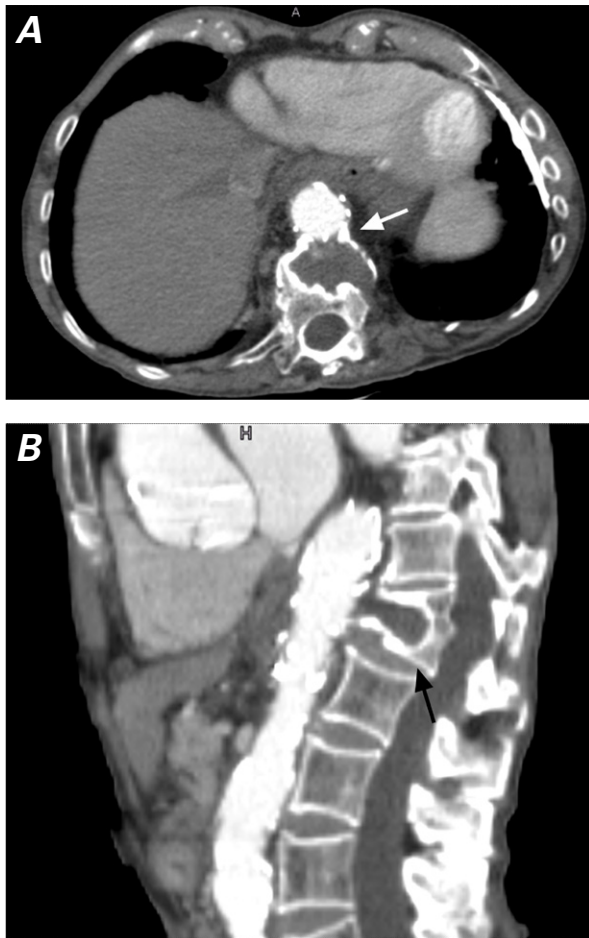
Computed tomograms. A) The axial view reveals the exclusion of the aortic false aneurysm (arrow). B) The sagittal view reveals the complete exclusion of the aortic false aneurysm and the absence of prosthetic endoleak (arrow).
